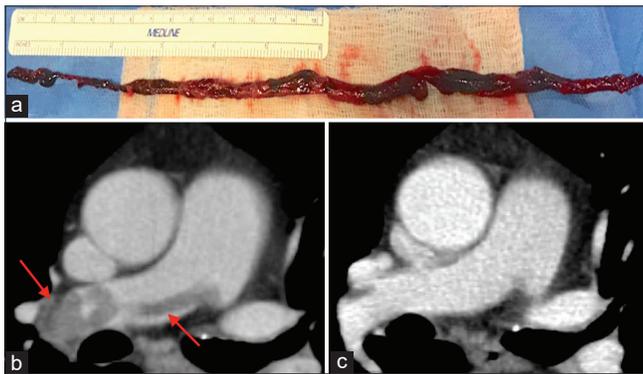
A 55-year-old male with recent hemicolectomy for colon cancer who presented with sudden onset dyspnea. (a) Approximately 12 in thrombus aspirated from the right pulmonary artery. (b) Pre-procedure contrast-enhanced computed tomography (CT) cross-section showing right and central portions of the bilateral thrombus (red arrow) before thrombectomy. (c) Post-procedure contrast-enhanced CT cross-section showing minor residual thrombus in the right pulmonary artery 7 weeks after thrombectomy.
